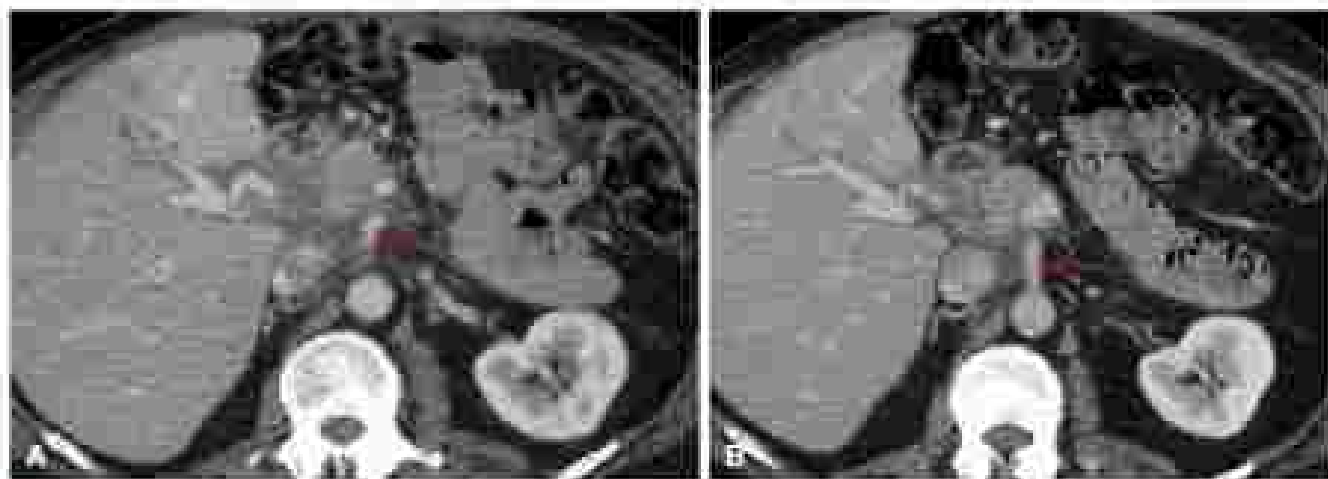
Axial images of a contrast-enhanced computed tomography scan from a 55-year-old man present to him type 1 autoimmune pancreatitis before (A) and after (B) steroid treatment. Images taken at the level of the superior mesenteric artery (arrow). Sterpy showed lymphoplasmacytic inflammation and a pancreatic intracholelithelial pain for immunoglobulin G4.
